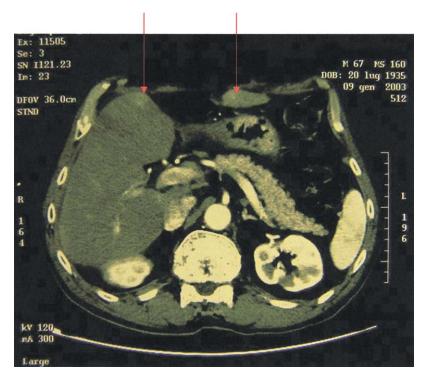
CT image of the liver. *Arrows* indicate two separate hepatocellular carcinomas, one in segment III and one in segment IV of the liver.
